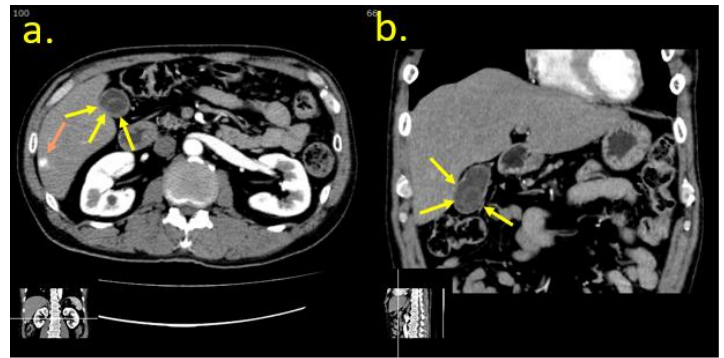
Enhanced abdominal CT scan (early phase)
